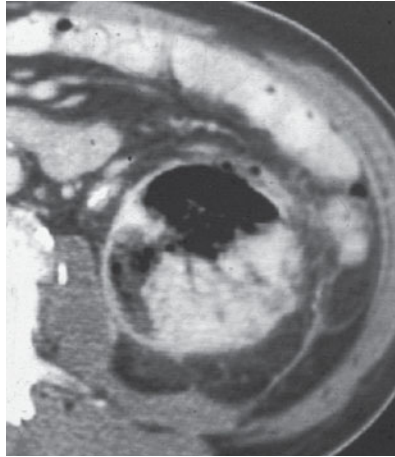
Contrast-enhanced CT. Emphysematous pyelonephritis. In addition to the signs of acute pyelonephritis, such as hyperattenuating areas and perirenal fat stranding, the image shows intrarenal gas
